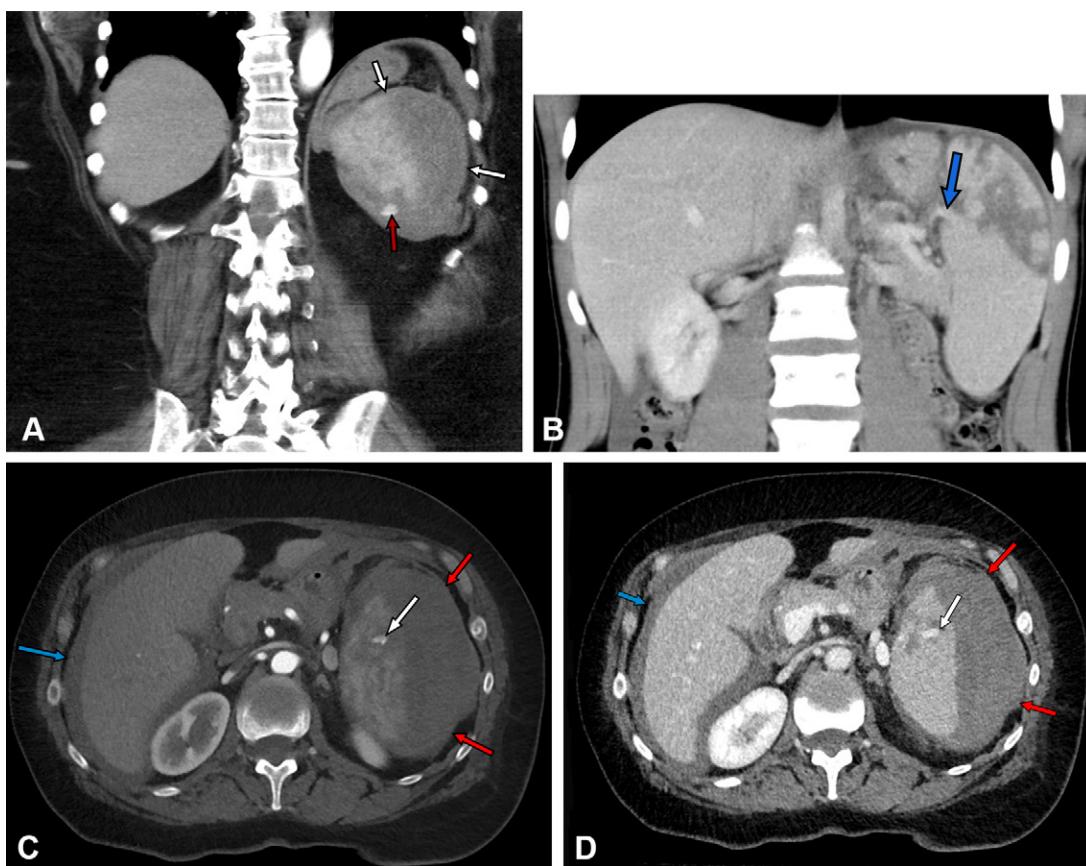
Grade IV splenic injuries according to the revised 2018 AAST-OIS. (A) Coronal contrast-enhanced CT image in a 27-year-old woman after a motor vehicle collision shows active contrast material extravasation (red arrow) consistent with bleeding contained within the splenic capsule (white arrows). Inclusion of splenic vascular injuries or active bleeding within the capsule was one of the main changes brought on by the AAST-OIS 2018 revision. The patient underwent angiography, which revealed no significant active extravasation or contained vascular injuries at the time of the procedure. Nevertheless, the mid splenic artery was empirically embolized with an 8-mm Amplatzer Plug II with good angiographic results. The patient made a full recovery. (B) Coronal contrast-enhanced CT image in a 15-year-old boy shows a large laceration of the upper pole of the spleen involving segmental vessel damage (arrow) and resulting in greater than 25% devascularization. An axial cine clip of this patient is shown in Movie 4. (C, D) Axial contrast-enhanced CT images in the arterial (C) and portal venous (D) phases in a 47-year-old man after a motor vehicle collision show a large subcapsular splenic hematoma (red arrows) and a small contrast material–attenuation focus within the spleen (white arrow), which follows the blood pool in both the arterial and portal venous phases. This focus showed washout at delayed imaging, compatible with contained vascular injury. Perihepatic bleeding is also noted (blue arrow). Inclusion of splenic vascular injuries or active bleeding within the capsule was one of the main changes brought on by the AAST-OIS 2018 revision.
